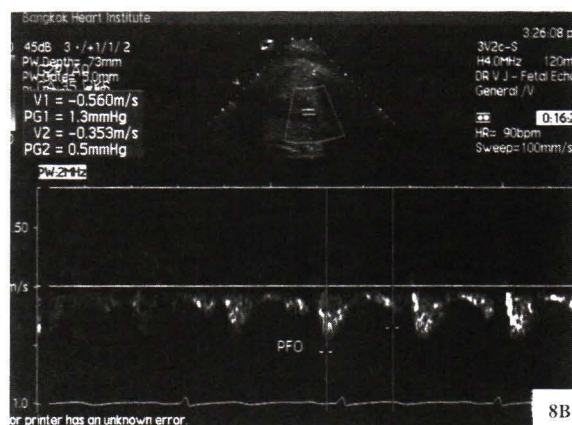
Doppler Color Flow Image and Pulsed Doppler of foramen ovale with right to left shunt from right atrium to left atrium.
